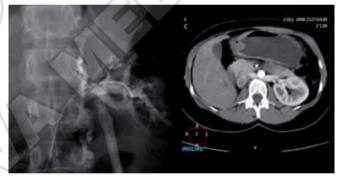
Retroaortic left renal compression .Left: venography using femoral access. Both renal vein compression and left ovarian vein reflux are present. Right: computed tomography scan of the same patient.
